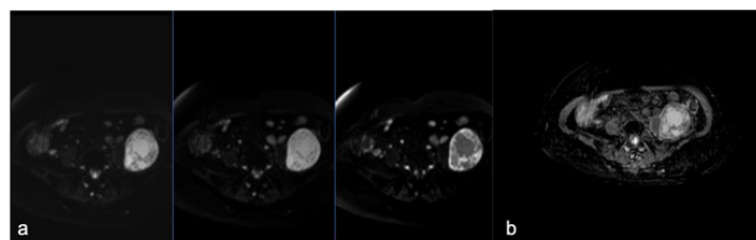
DWI images (b0,400,800) (a) and corresponding ADC map (b)
